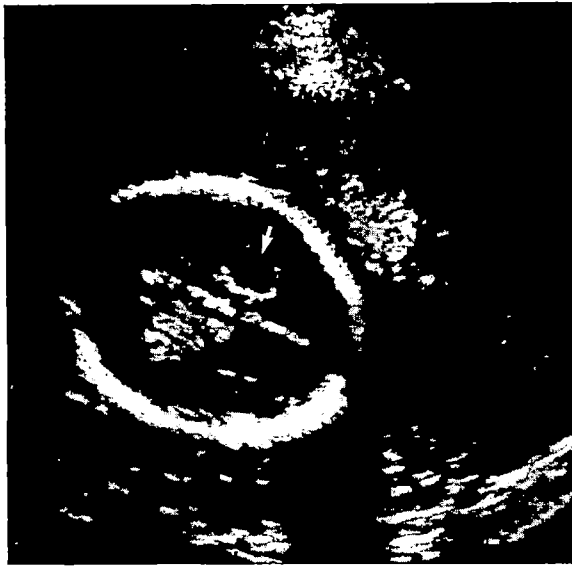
Transverse view through fetal head at 20 weeks' gestation shows unilateral choroid plexus cyst (*arrow*). Cyst was gone at time of repeat ultrasonogram 1 month later.
